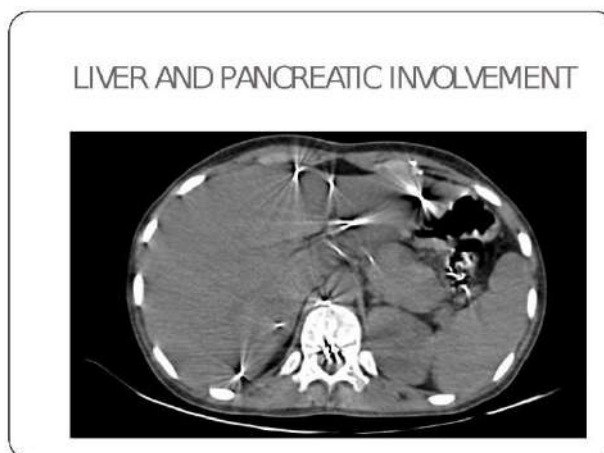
shows CT abdomen with dense radio opacities in liver and pancreas.
